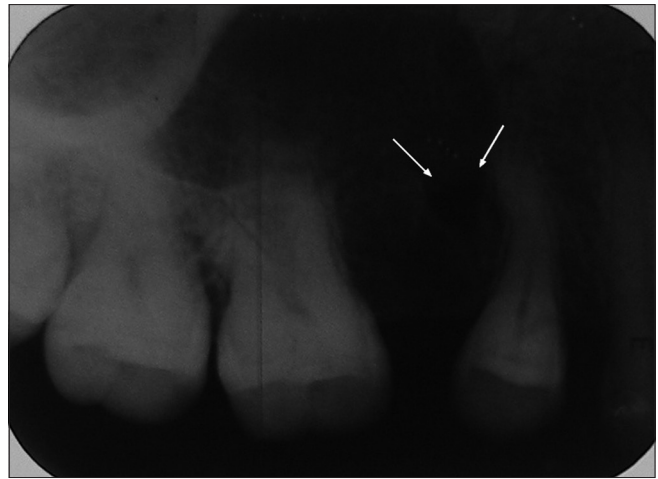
Intraoral periapical radiograph showing ovoid radiolucent area
